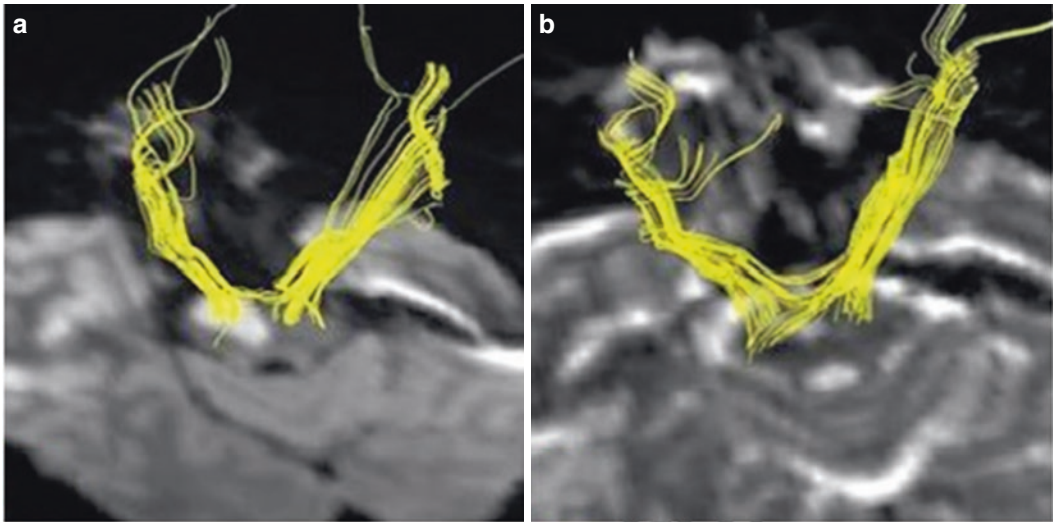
Right pontine infarction. A 60-year-old male patient who presented with left hemiplegia and dizziness. Transverse DWI shows right pontine infarction, and transverse DTT shows that nearly the entire right corticospinal
